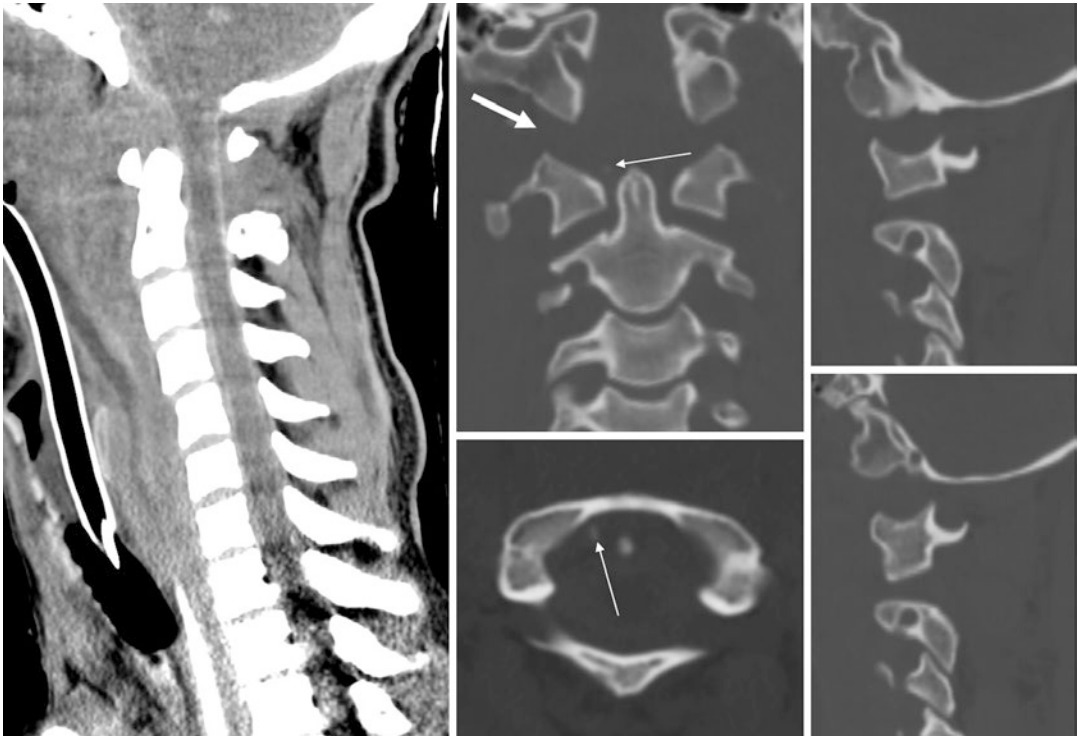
Occipitoatlantal and atlantoaxial dissociations: 2D-reformatted midsagittal and coronal, source axial, and 2D-reformatted right and left sagittal CT images. Occipitoatlantal (*thick arrow*) is greatly more severe than atlantoaxial dislocation. Note the massive prevertebral
